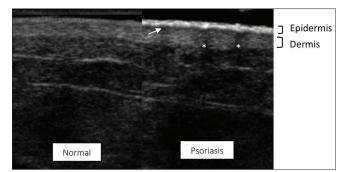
The sonographic features of skin on the thigh in a healthy participant and a participant with psoriasis. In the patient with psoriasis, the epidermis is thickened and more hyperechoic, a hypoechoic band (arrow) is visible between the epidermis and dermis and acoustic shadows (asterisks) are visible beneath two focal areas of epidermal thickening
